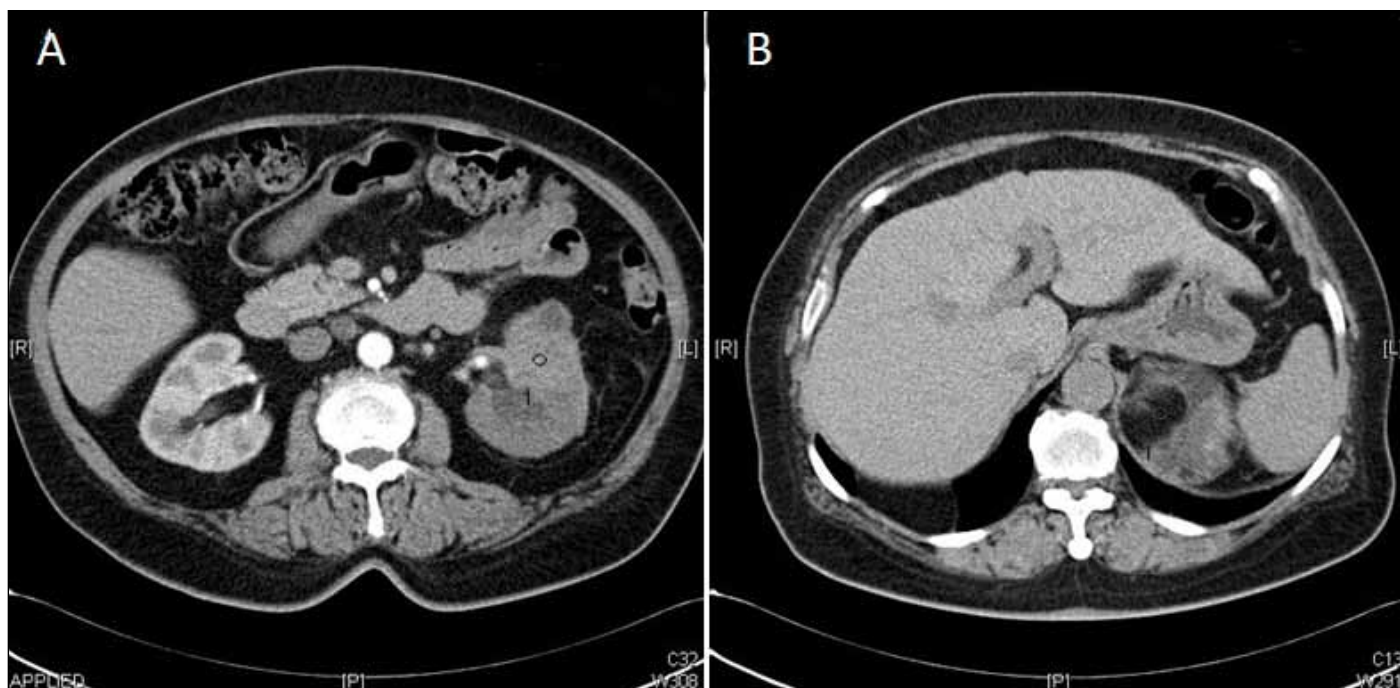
Computed tomography (CT) scans revealed a mass in the kidney which presented moderate heterogeneous enhancement in enhancement CT scans (A) (oval mark) and a mass in the left adrenal gland area which presented a number of fat-density inside (B) (oval mark).
